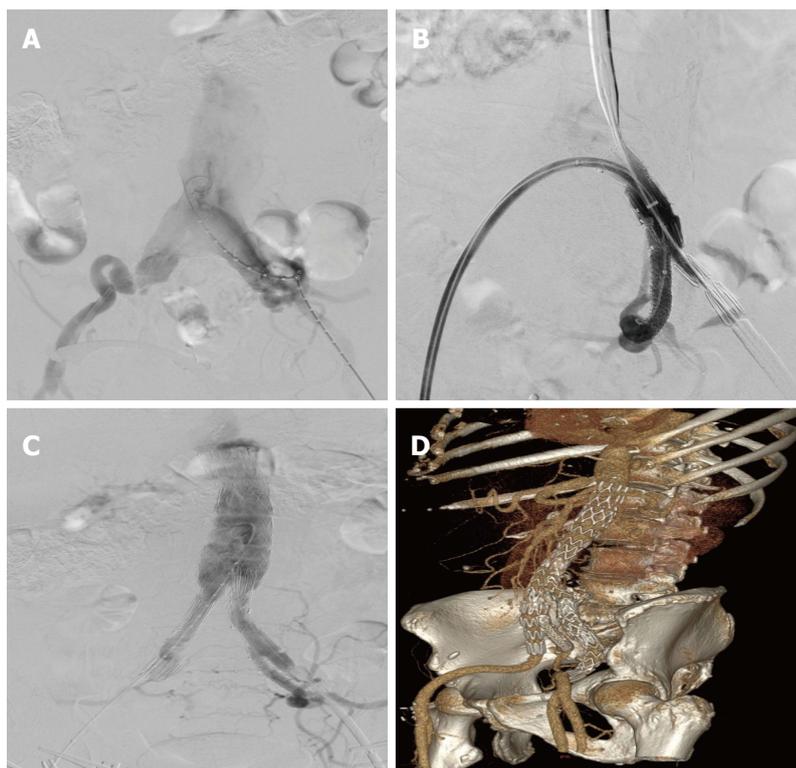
A 68-year-old male with an abdominal aortic aneurysm and an iliac artery aneurysm. A: Preoperative angiography; B: Control angiography after the placement of an Advanta stent graft in the left internal iliac artery without endoleak; C: Control angiography after the deployment of IBD and a bifurcated stent graft; D: Computed tomography angiography and three dimensional reconstruction at 3 mo. IBD: Iliac branch device.
